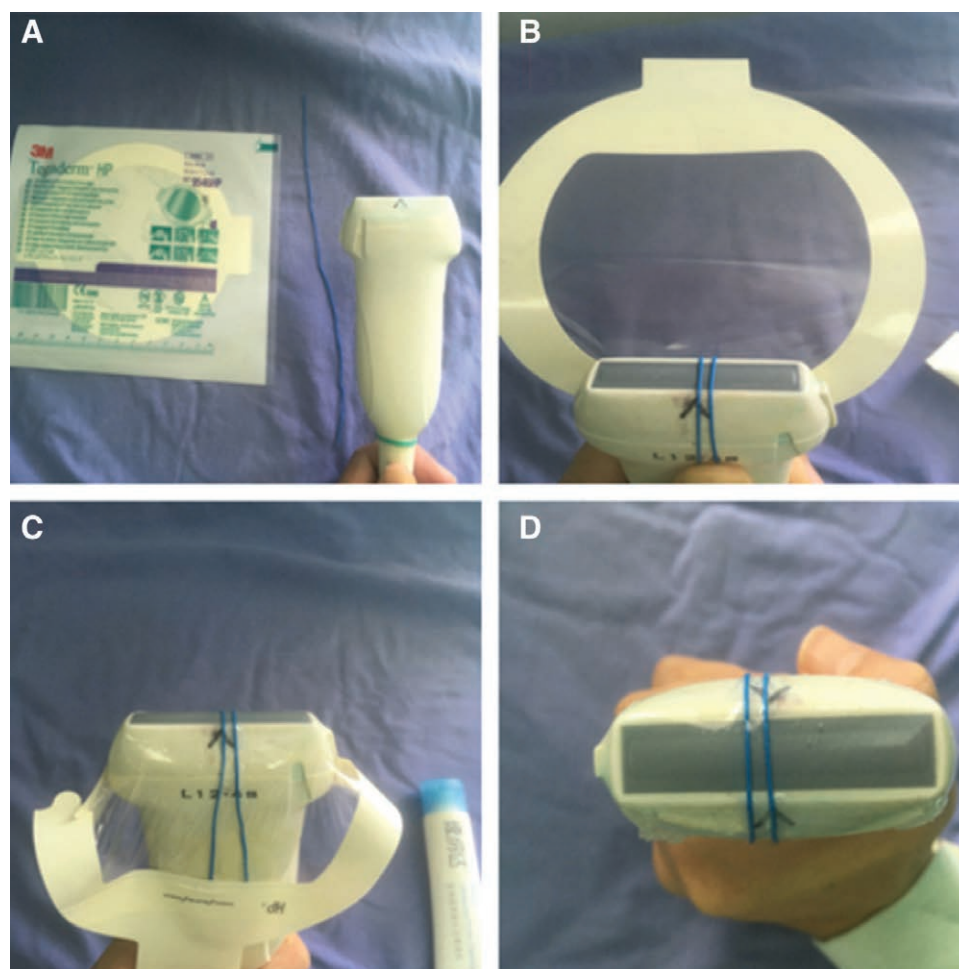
The double developing lines on the ultrasound probe. Double parallel developing lines were bound to the midpoint of the ultrasound probe perpendicular to its long axis. (A) The ultrasound probe, the developing line, and the sterile 3M membrane. (B) The developing line was bound as double parallel lines on the midpoint of the ultrasound probe perpendicular to its long axis. The ultrasonic couplant was added on the ultrasound probe. (C) Sterile 3M membrane was used to cover the ultrasound probe. (D) The front view of double developing lines on the ultrasound probe.
